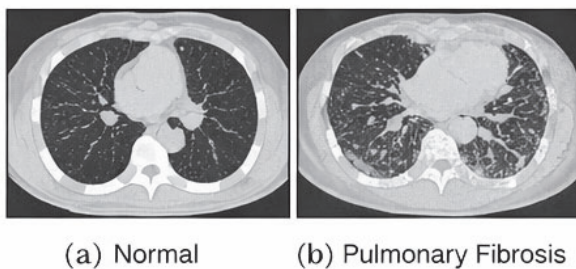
Sample CT scan images of (a) normal lung and (b) pulmonary fibrosis cases.
